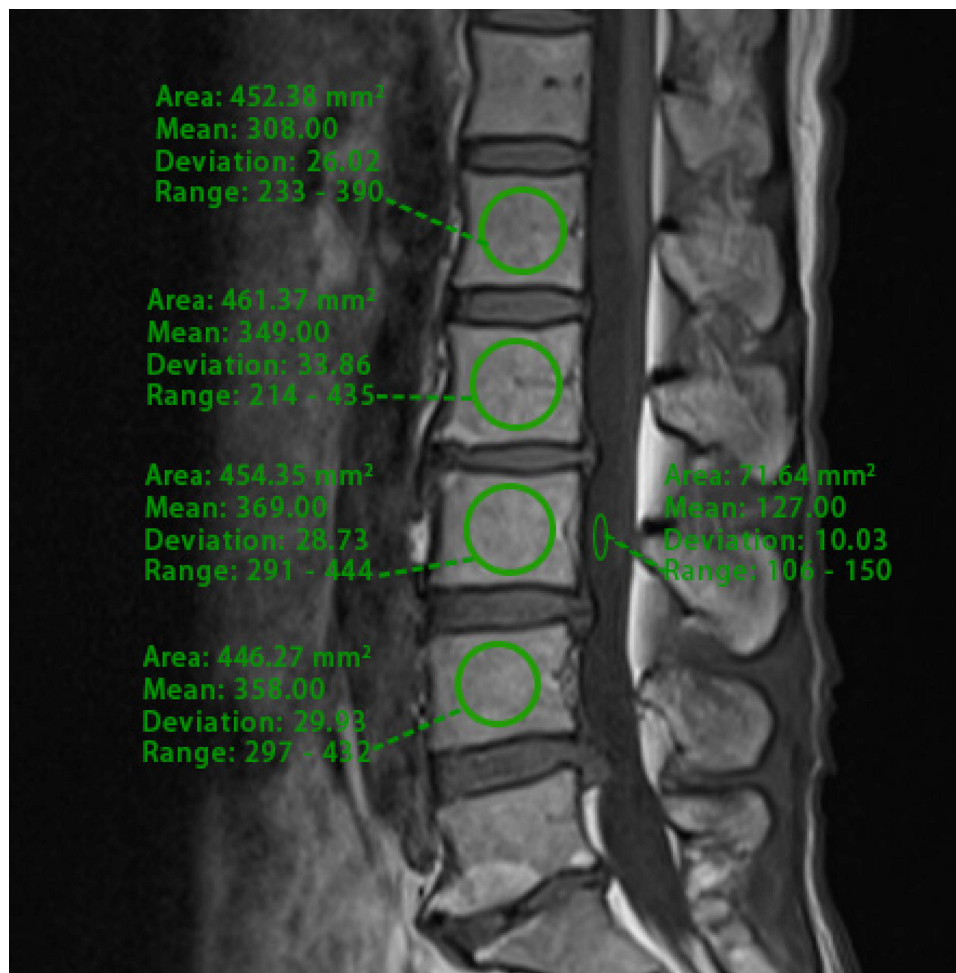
Sagittal non-contrast-enhanced T1-weighted MRI of the lumbar spine was conducted with ROI positioned at the vertebral bodies of L1-L4 and at the CSF level at L3 using the PACS.
